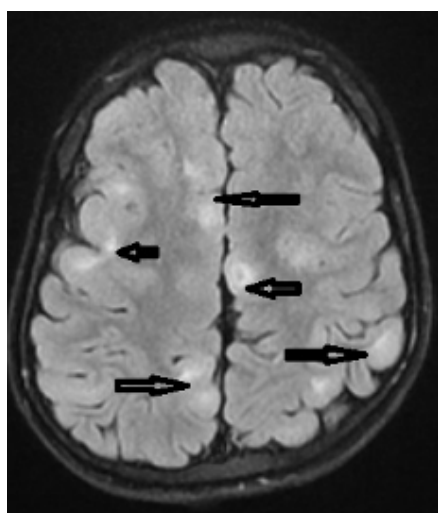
Axial FLAIR MRI shows multiple cortical tubers (black arrow).
